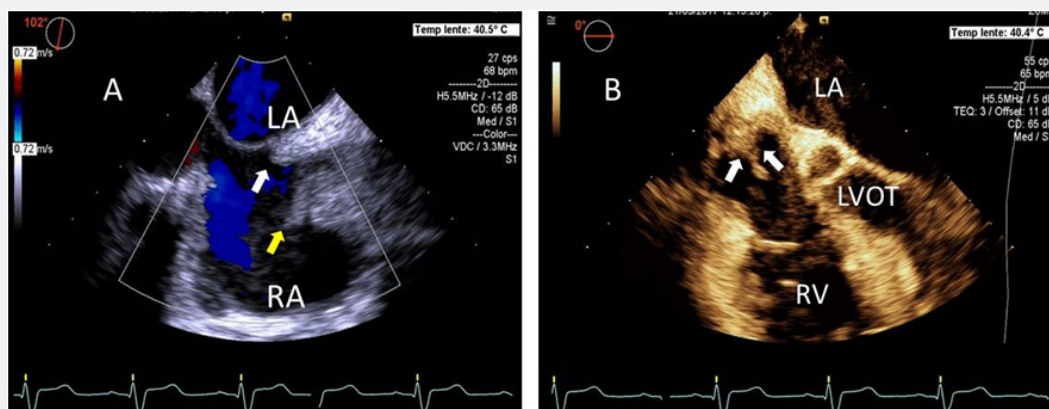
Transesophageal study: A) Transesophageal two dimensional image with color Doppler at 102° showing the both atria. In the superior vena cava large vegetation is observed (yellow arrow) and a thickness of the superior portion of the interatrial septum suggesting an abscess (white arrow). B) Transesophageal four chamber view showing vegetations attached to the roof of the right atrium (white arrows). RA: Right Atrium; LV: Left Ventricle; RV: Right Ventricle; LVOT: Left Ventricular Outflow Tract.
